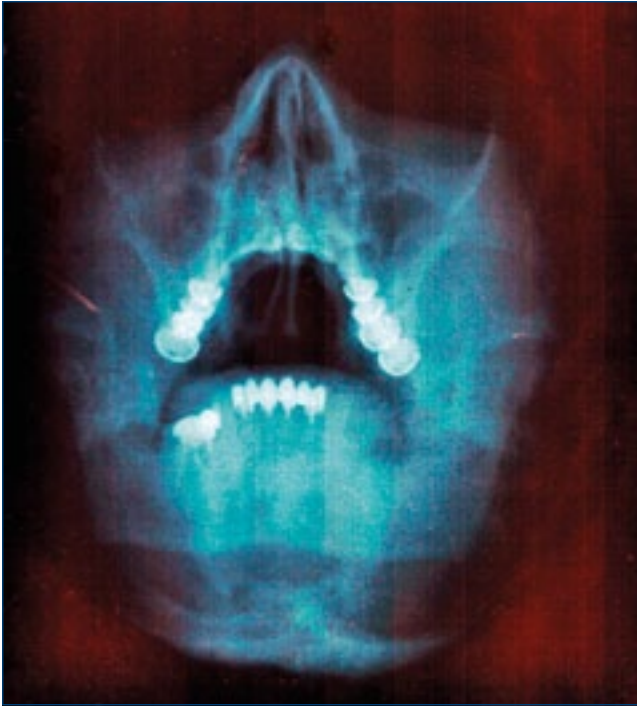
Anterior Face Sinuses X-ray (2012)
